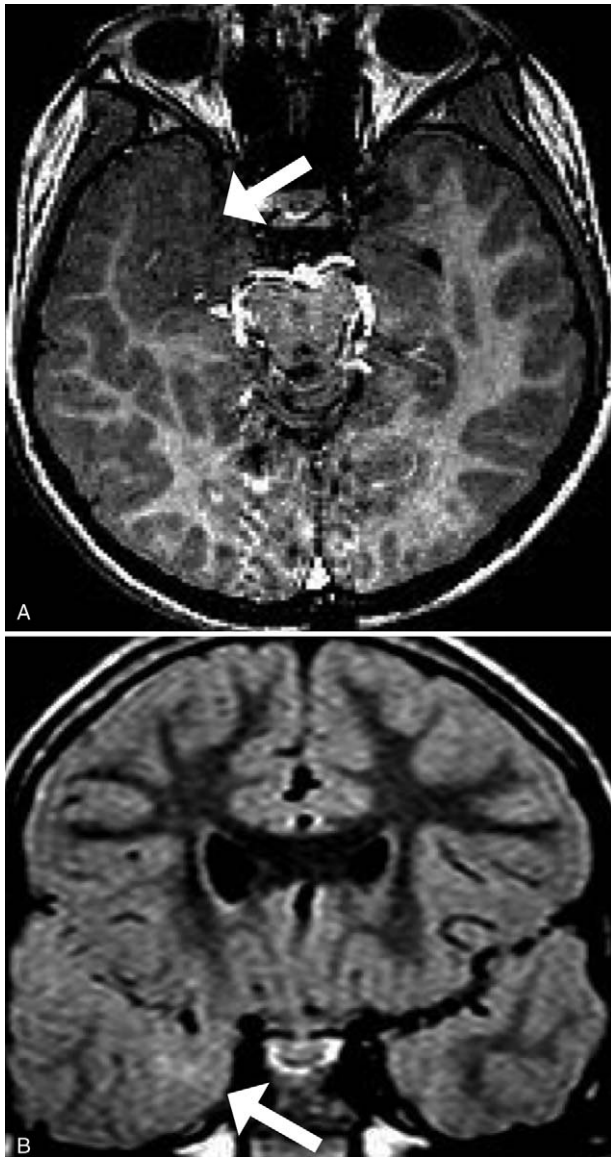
Young adult female with incontinentia pigmenti. Axial contrast-enhanced T1-weighted (A) and coronal T2-FLAIR (B) images show cortical dysplasia in the right temporal lobe (white arrows) characterized by thickening of the cortex, blurring of the grey-white matter junction, and FLAIR signal hyperintensity of the subcortical white matter.
